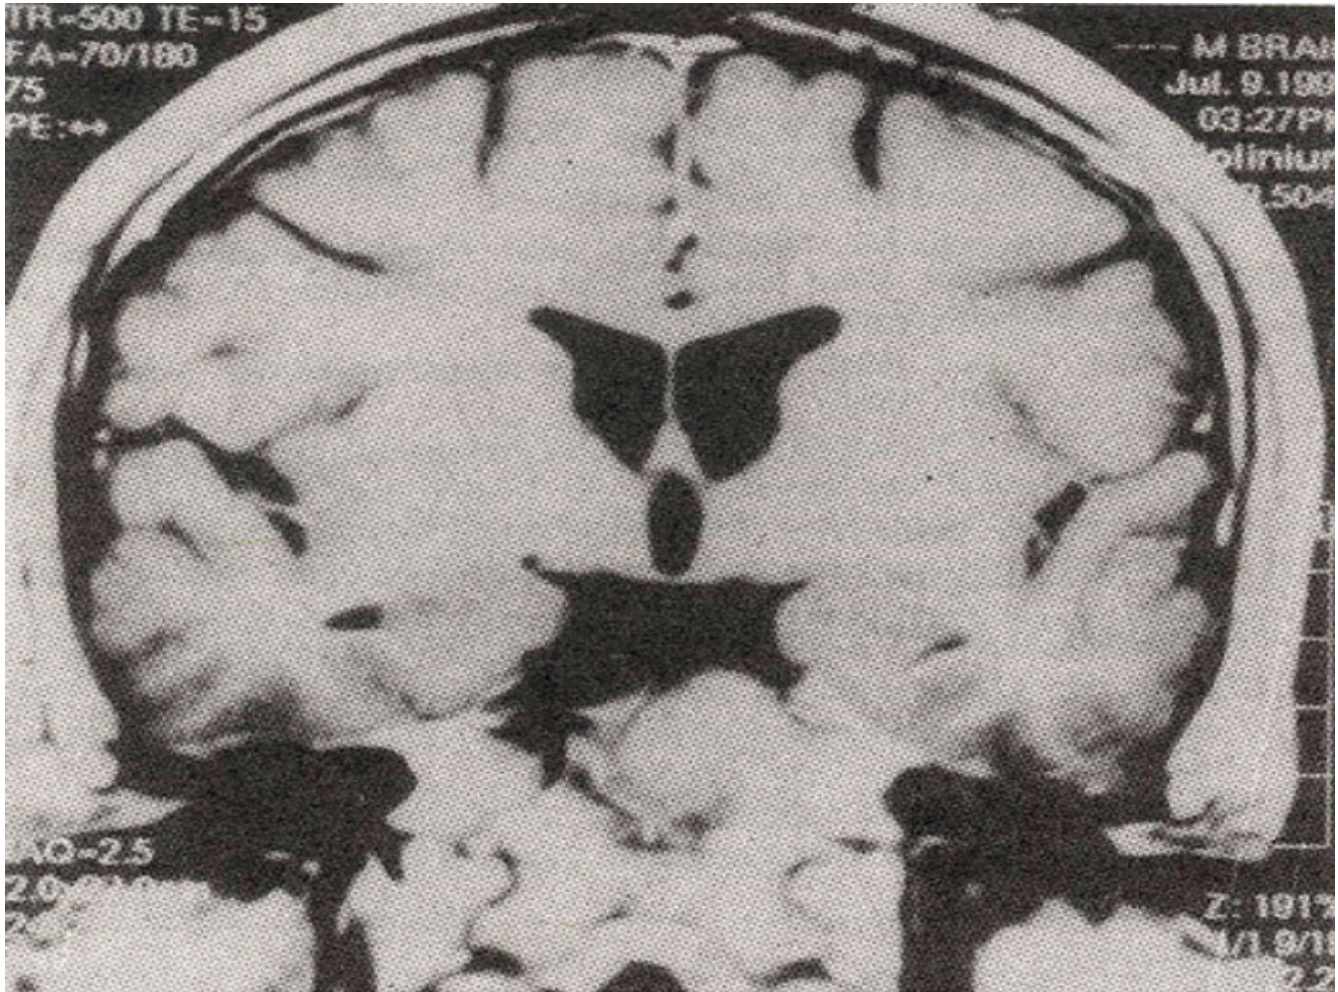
MRI (Coronal) with showing the mass as hypodense signal on T2 weighted image.
